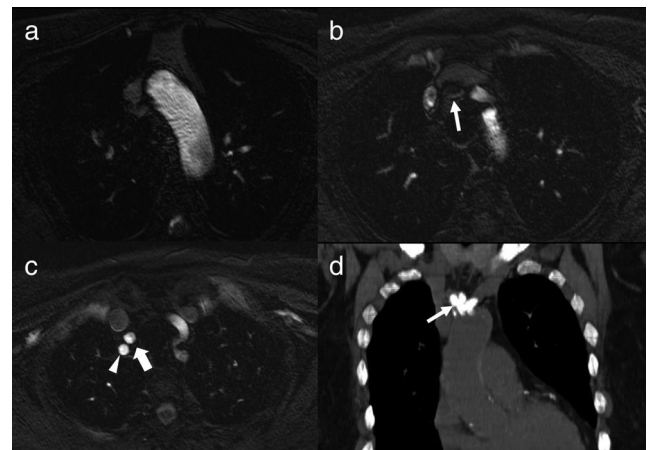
QISS MRA of high-grade innominate artery stenosis or occlusion in a 77-year-old woman with severe chronic kidney disease who was admitted with a right cerebral hemispheric infarction. Sequential QISS MRA images (a–c) demonstrate minimal to no flow in the innominate artery (thin arrow), with reconstitution of the right subclavian artery (arrowhead) and right common carotid artery (thick arrow) distally. Coronal non-contrast MIP CT image (d) demonstrates extensive calcification involving the origin of the innominate artery (thin arrow). The patient was managed with a surgical aorto-innominate arterial bypass procedure.
